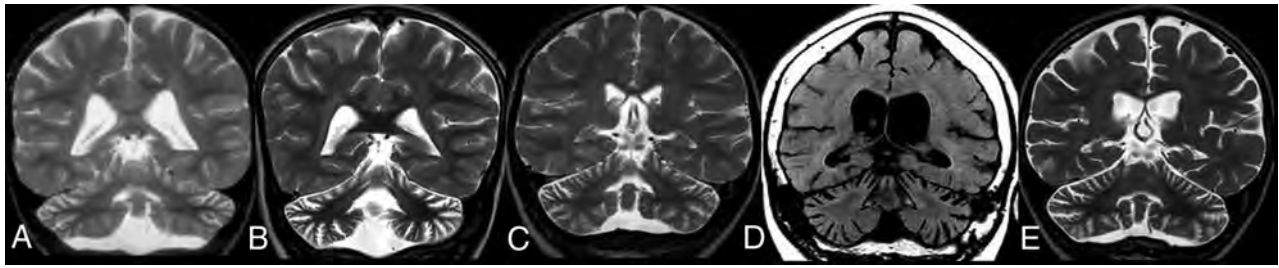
CLN7 disease. Coronal T2-weighted MR imaging of 4 different patients (A, B, C, and E) and coronal reformatted CT of 1 patient (D). Note cerebellar more than cerebral volume loss in all patients.
